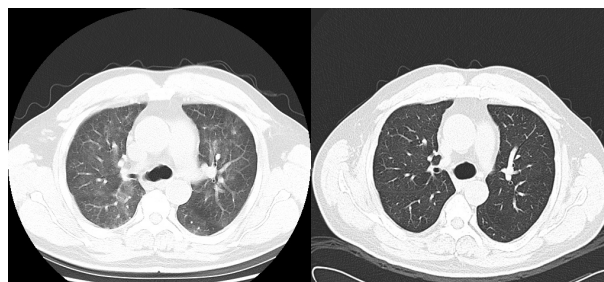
Helical computed tomographic scanning showed ground-glass shadowing in bilateral lungs before prednisone treatment and a recovery at 1 week post-treatment.
